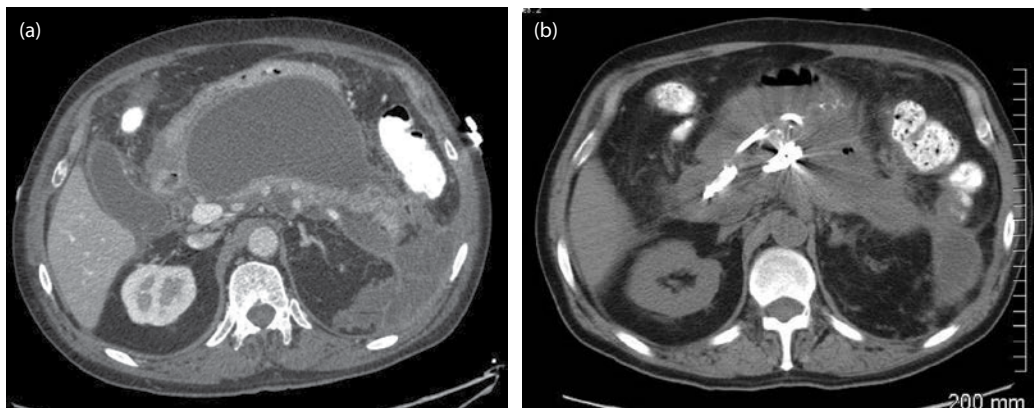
The previous patient CT images before and after endoscopic necrosectomy. (a) CT scan with well-demarcated WON compressing the gastric lumen. (b) Four weeks after successful transgastric endoscopic necrosectomy.
